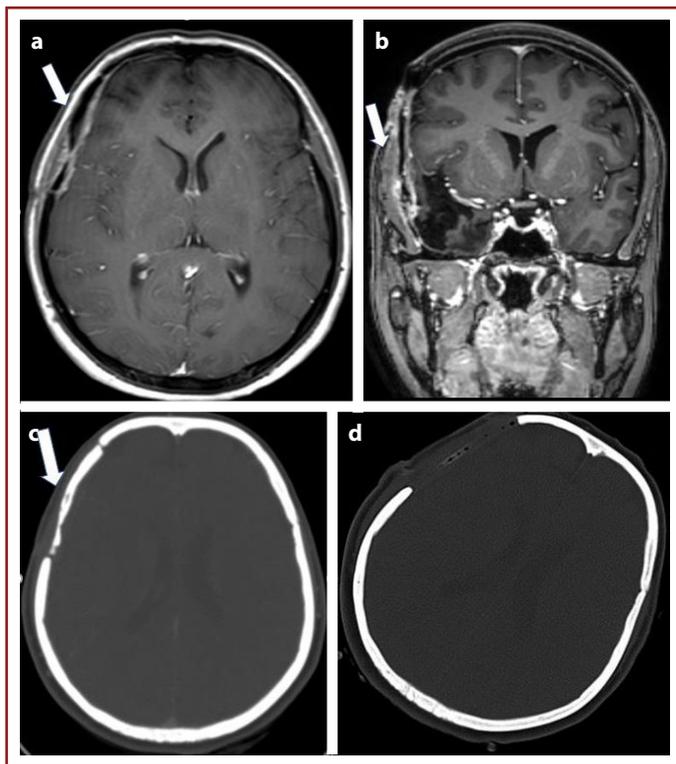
A female patient aged 36 years admitted due to purulent discharge from the flap forming a fistula on the skin and swelling in the wound site 2.5 months after the surgery for meningioma that is located in the temporal fossa. Magnetic resonance imaging with contrast demonstrated: (a) linear contrast enhancement in the epidural space in the right temporal lobe indicated with a white arrow stands out. (b) Image of the coronal section shows extensive contrast involvement in the bone flap and swelling in the temporal muscle implicates of bone flap osteomyelitis, (c) In the computed tomography scan given before the debridement, irregularities in the bone flap in the right temporal lobe shown with the white arrow stand out. (d) Early postoperative computed imaging after bone flap removal
